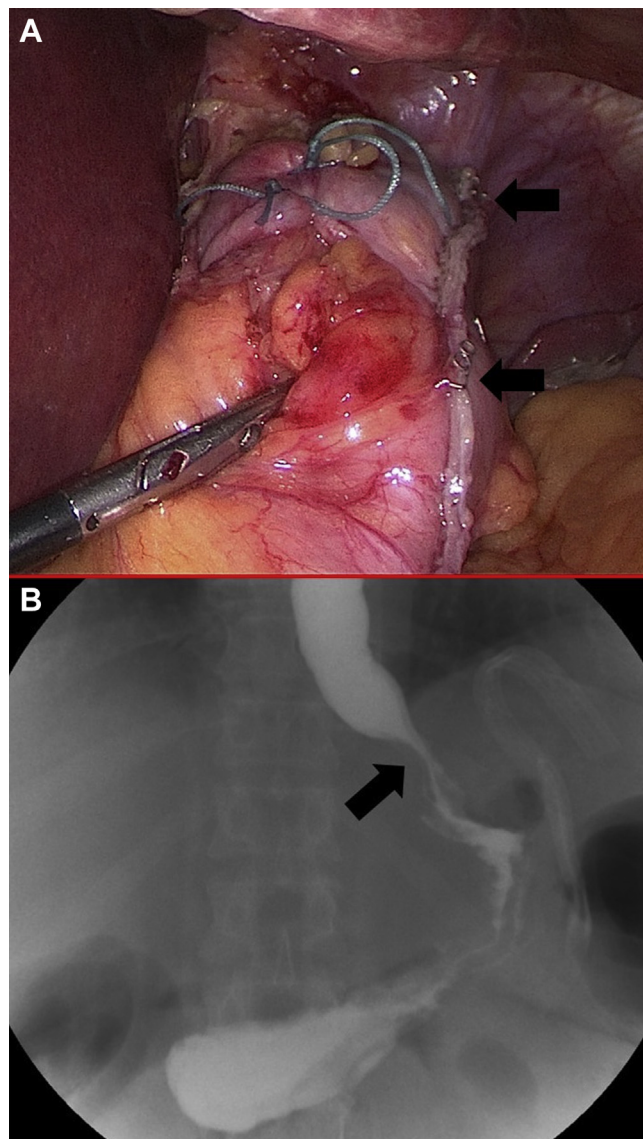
This is a surgical result. A very short fundoplication, in the right position, with a gastric fundus resection as complete as possible (A). Gastroesophageal X-ray with water-soluble contrast by mouth on second postoperative day (B).
